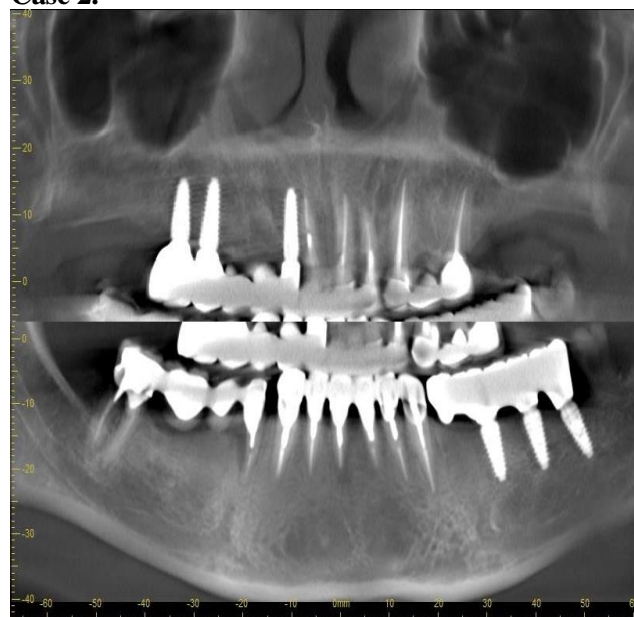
Preoperative CT showing periapical lesions in the 44 tooth region
